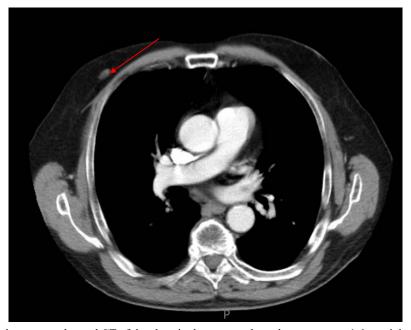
Axial contrast enhanced CT of the chest in the venous phase demonstrates a 1.6 cm right breast nodule.
